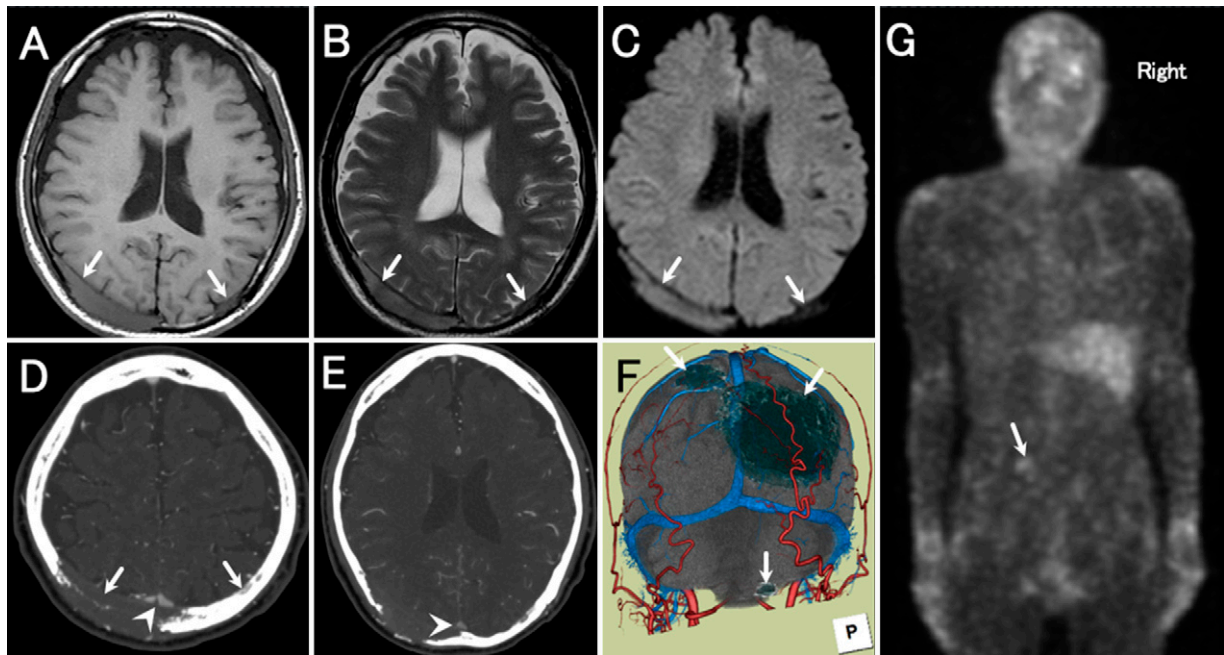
Presurgical radiological findings. A–C: MRI showing bilateral occipitoparietal lesions (*white arrows*) with isointensity on T1-weighted imaging, isointensity on T2-weighted imaging, and mild hyperintensity on diffusion-weighted imaging. D and E: Contrast-enhanced computed tomography showing that the bone was replaced by tumors (*white arrows*) and that the lesions were adjacent to the superior sagittal sinus (*white arrowheads*). F: A reconstructed image showing three separate lesions (*white arrows*). G: Gallium scintigraphy revealed uptake only in the pelvic bone (*white arrow*) and skull.
